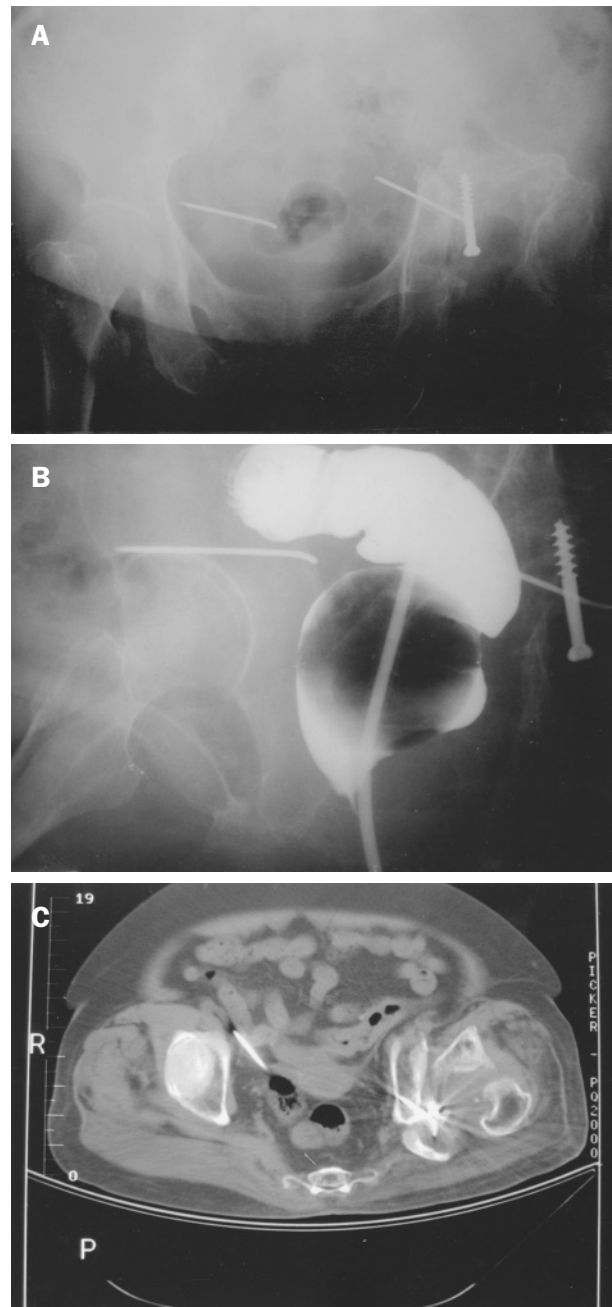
Anterior-posterior radiograph of the pelvis (A), bowel contrast studies (B), and a computed axial-tomographic scan (C), showing the location of the Kirschner wire without associated gastrointestinal or urinary injury.
